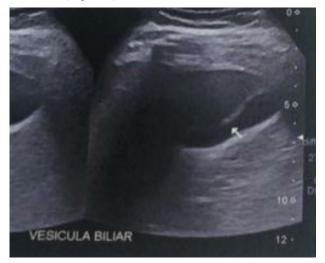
Ascaris lumbricoides in gallbladder in ultrasonography (US)
